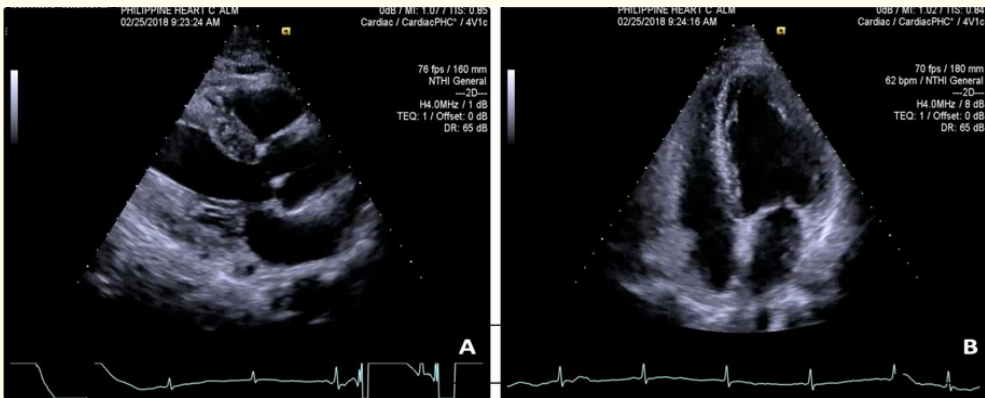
Two dimensional echocardiogram (A. PLAX view. B. A4C view) showing concentric left ventricular hypertrophy and adequate wall motion, contractility and systolic function. Aortic valve sclerosis. Mitral valve sclerosis with mild mitral regurgitation. Trivial tricuspid regurgitation. Normal pulmonary artery pressure with pulmonic regurgitation.
